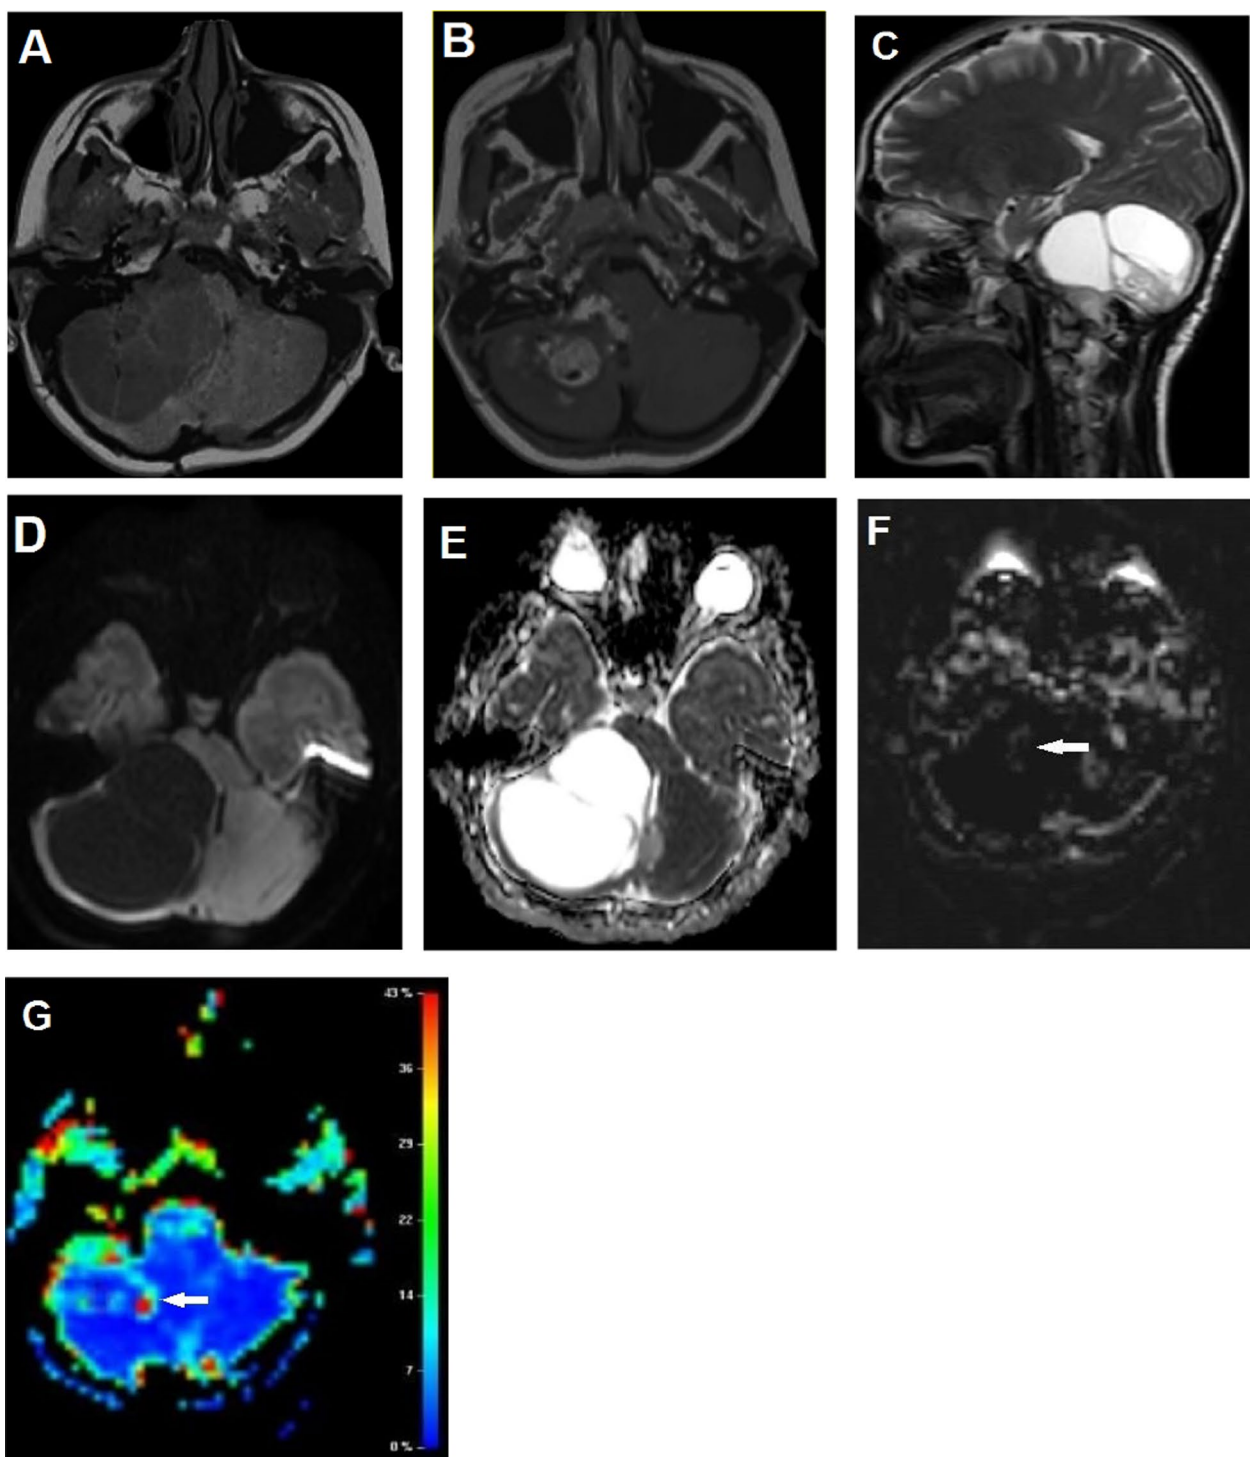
A 14-year-old girl patient with a WHO grade I pilocytic astrocytoma. Images show a well-defined cystic lesion in the right cerebellar hemisphere with internal septae and solid mural nodule. It displays low signal intensity on axial T1WI (A) with enhancing mural nodule on post contrast axial T1WI image (B). It displays high SI of the cystic part with intermediate SI of the mural nodule on sagittal T2WI (C). Free diffusion of the lesion is seen in the form of low SI on DWI (b1000 image) and high SI on axial ADC grayscale map (D, E). Hypo-perfusion of the cystic parts with small area of hyper-perfusion (white arrows) corresponding to the solid mural nodule is seen in the axial ASL grayscale and color CBF maps (F, G)
